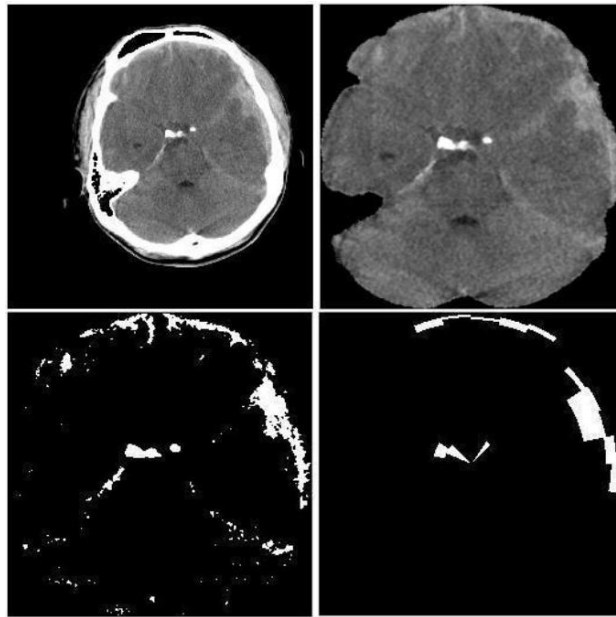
Constructing binary feature vector from TBI CT image: example 1
